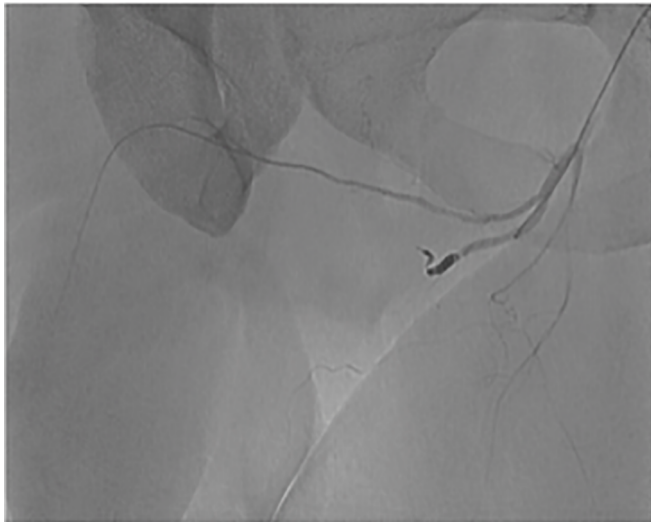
The Embolized Artery. CT angiography image that shows the platinum coil located in the internal pudendal artery. One can appreciate there is no longer flow into the fistula or distal to the coil indicating successful occlusion.
